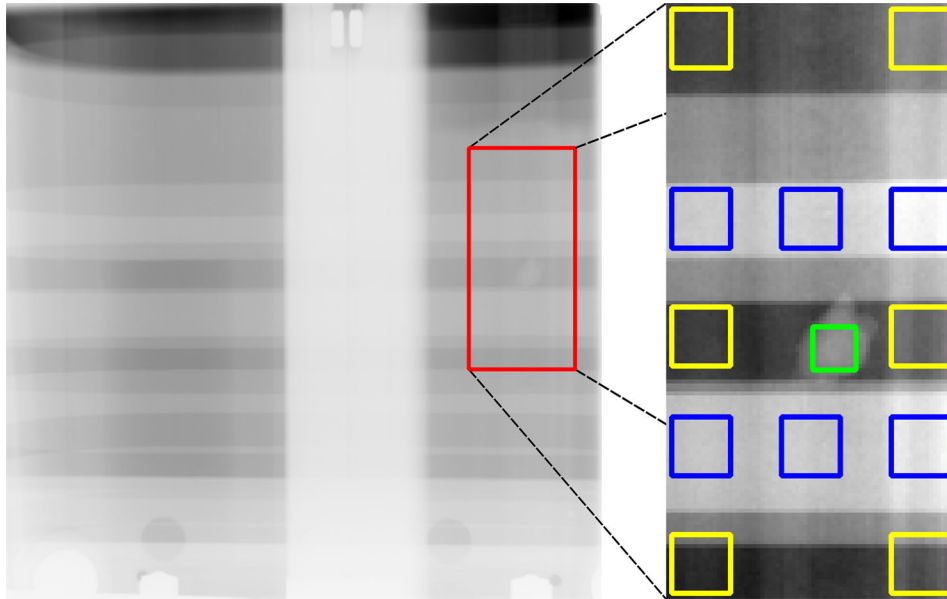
Location of regions of interest (ROIs) in the original X-ray image used for contrast evaluation (lung, bone, and tumor segments are presented in yellow, blue, and green colors, respectively). Six ROIs of lung tissue (yellow rectangles) were defined at the corners and the vertical center of the ROI encompassing the whole motion range (red rectangle). Additionally, six ROIs of rib tissue (blue rectangles) were defined within the rib segments and one ROI within the tumor. The positions were chosen to investigate the influence of bone suppression (BS) on the bone/lung, bone/tumor, and tumor/lung contrast. The entire ROI (red rectangle) was used for fitting the intensity transfer function (ITF) to establish an intensity transformation between the digitally reconstructed radiograph (DRR) and the X-ray imaging domain
